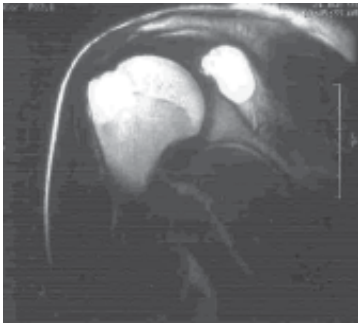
Preoperative shoulder MRI.
